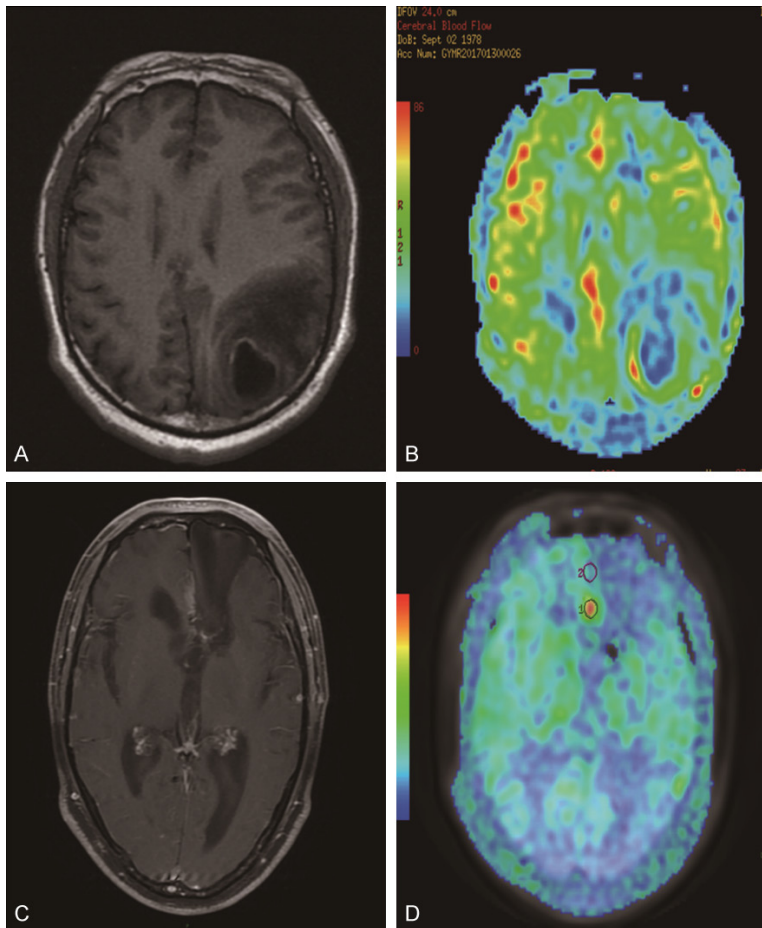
MRI and 3D-ASL results of disease recurrence and radiation-induced injury after glioma injury. A: A male patient aged 44 years old was diagnosed with recurrent gliomas confirmed by the follow-up and enhanced T_2 WI indicates obvious linear intensification in lesions. B: 3D-ASL CBF false-color images display the hyper-perfusion zone corresponds to the enhancement zone (rCBF = 1.25). C: A female patient aged 39 years old is confirmed to be radioactively damaged by the follow up and enhanced T_1 WI indicates annular anomalous intensification in the enhanced round edge. D: 3D-ASL CBF false-color images manifest weak intensification around the lesion sites after enhancement, and that the intensification range was small. Marker 1 shows the site of radiation-induced injury, and Marker 2 is the control point. MRI, magnetic resonance imaging; 3D-ASL, three-dimensional arterial spin labeling; T_2 WI, T_2 -weighted image; rCBF, relative cerebral blood flow; T_1 WI, T_1 -weighted image; CBF, cerebral blood flow.
